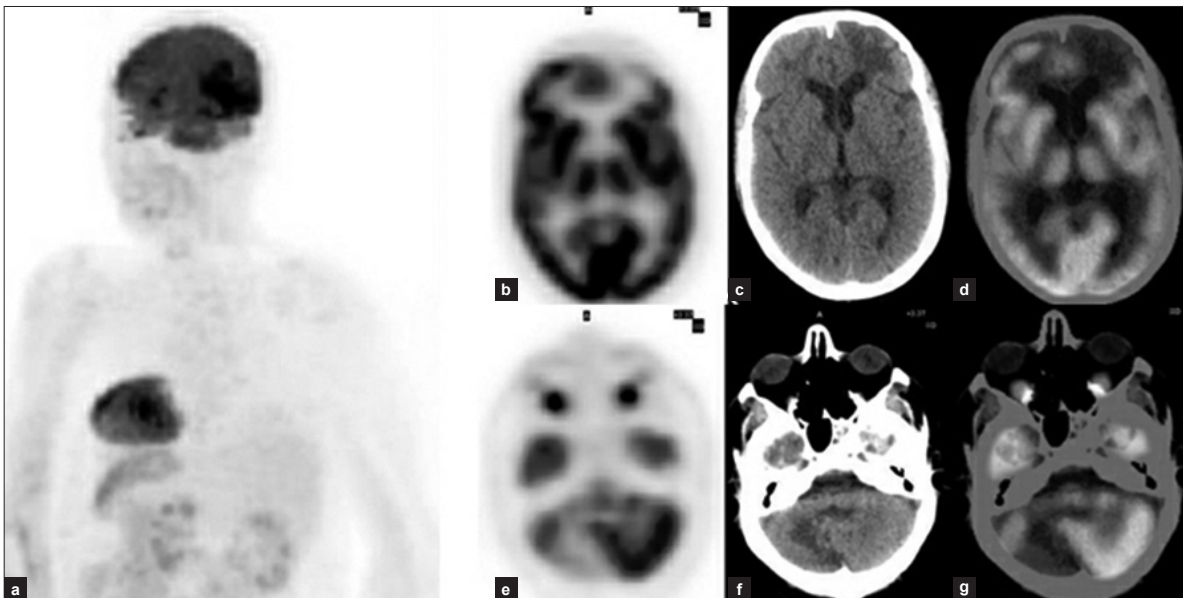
53-year male treated case of NHL; (a) Right oblique MIP of the brain showing hypometabolism in the cerebellar region; (b, c, d) Axial plain PET, CT and fused PET/CT images show hypometabolism in the left frontal lobe corresponding to a hypo-dense lesion on CT; (e, f, g) Axial plain PET, CT and fused PET/CT images at cerebellar level show hypometabolism in the right cerebellar hemisphere corresponding to a hypo-dense lesion on CT
